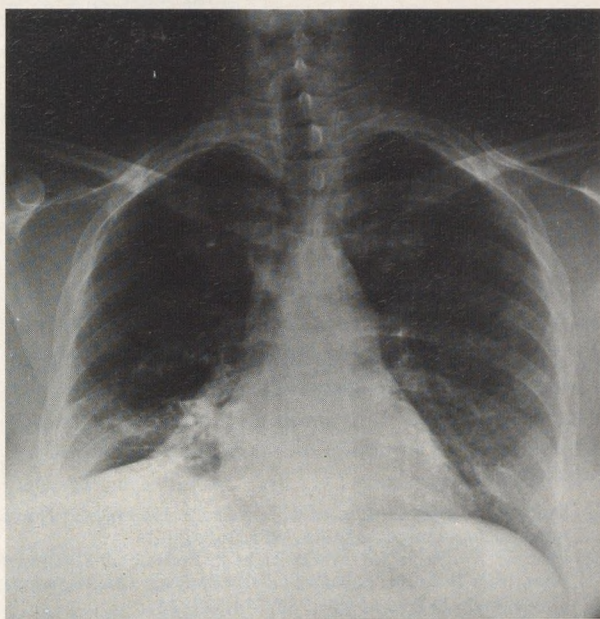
Chest radiograph 2 months after discharge showing persistent disease with a pleural effusion in the right lower lobe. The patient continues to receive oral itraconazole.
